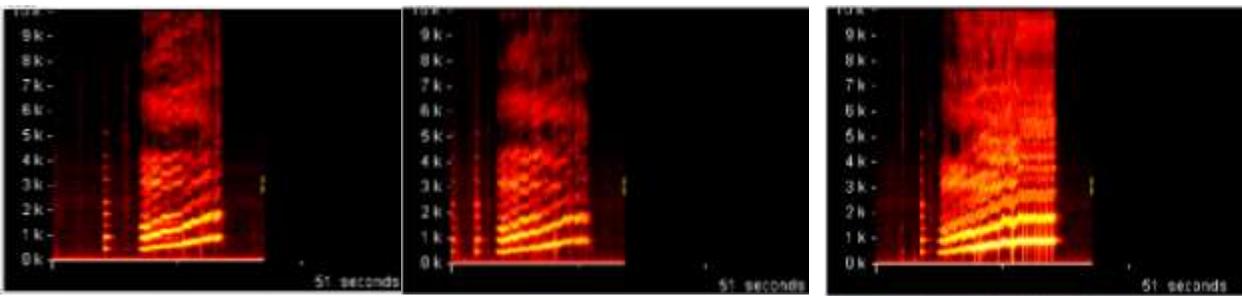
Sonogram. Ascending major scale. Left and center: stopovers without passage or coverage; right: with coverage to prepare the passage. The three performances are by the same singer (Soprano).
